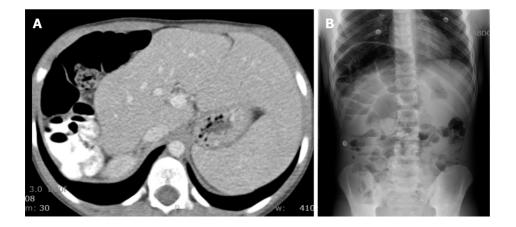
Imaging of abdomen and pelvis of a 12-year-old male with Chilaiditi syndrome and constipation. A: Computerize tomography. Marked air and fecal retention of the entire colon with colonic interposition above the liver with displacement of the liver leftwardly. This phenomenon indicates segmental agenesis of the right lobe of the liver and relaxation of the hepatic suspensory ligament; B: Plain X-ray. Markedly greater than average amount of fecal material particularly in the rectosigmoid colon. Few air fluid levels in the distal small bowel and air filled colonic loops that reach the right hemidiaphragm.
